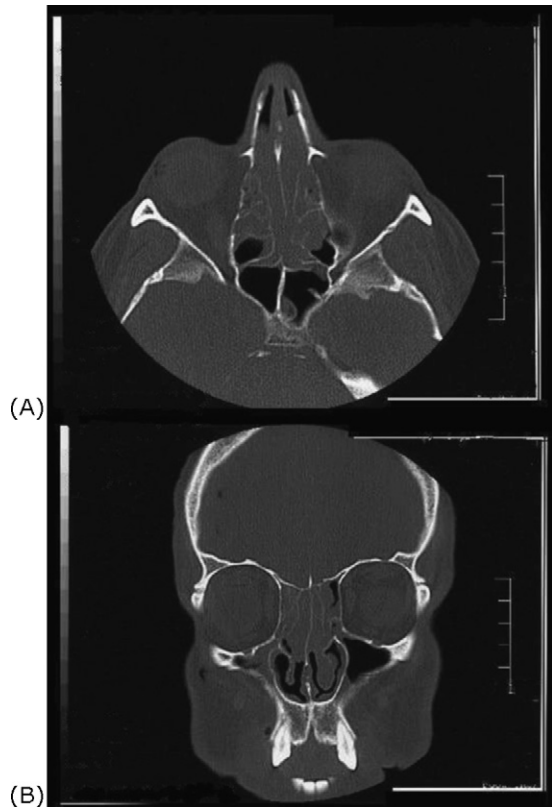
Axial (A) and coronal (B) CT scan of the skull showing a bilateral nasal homogeneous mass occupying the ethmoid and the ostiomeatal complex bilaterally.
